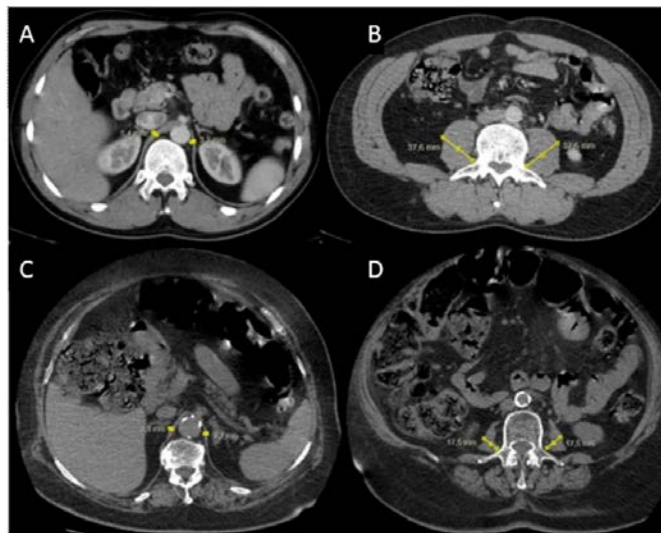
Axial contrast-enhanced computed tomography images of 34-year-old male (A, B) and 74-year-old female (C, D) patients showing measurements of maximum diaphragm thickness (A, C) at the celiac artery origin level and psoas muscle diameter (B, D) at the level of L3 vertebra (marked by yellow arrows).
